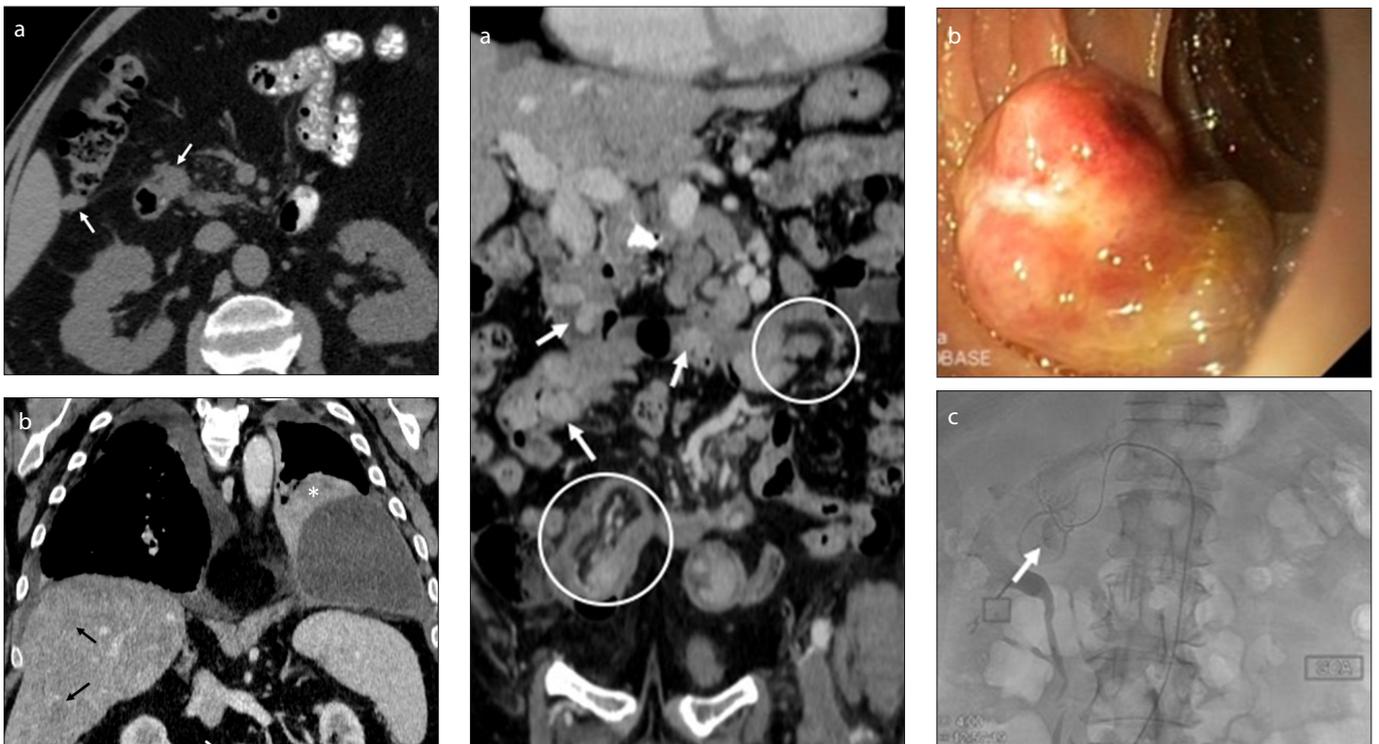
a, b. Axial unenhanced CT image (a) shows periduodenal and pericolic implants (*arrows*) in a patient with a subungual melanoma (hematogenous or peritoneal spread). Curved-coronal reconstructed contrast-enhanced CT image (b) shows a hypervascular duodenal implant (*white arrows*) and liver metastases (*black arrows*) in a patient with lung cancer (*asterisk*).
